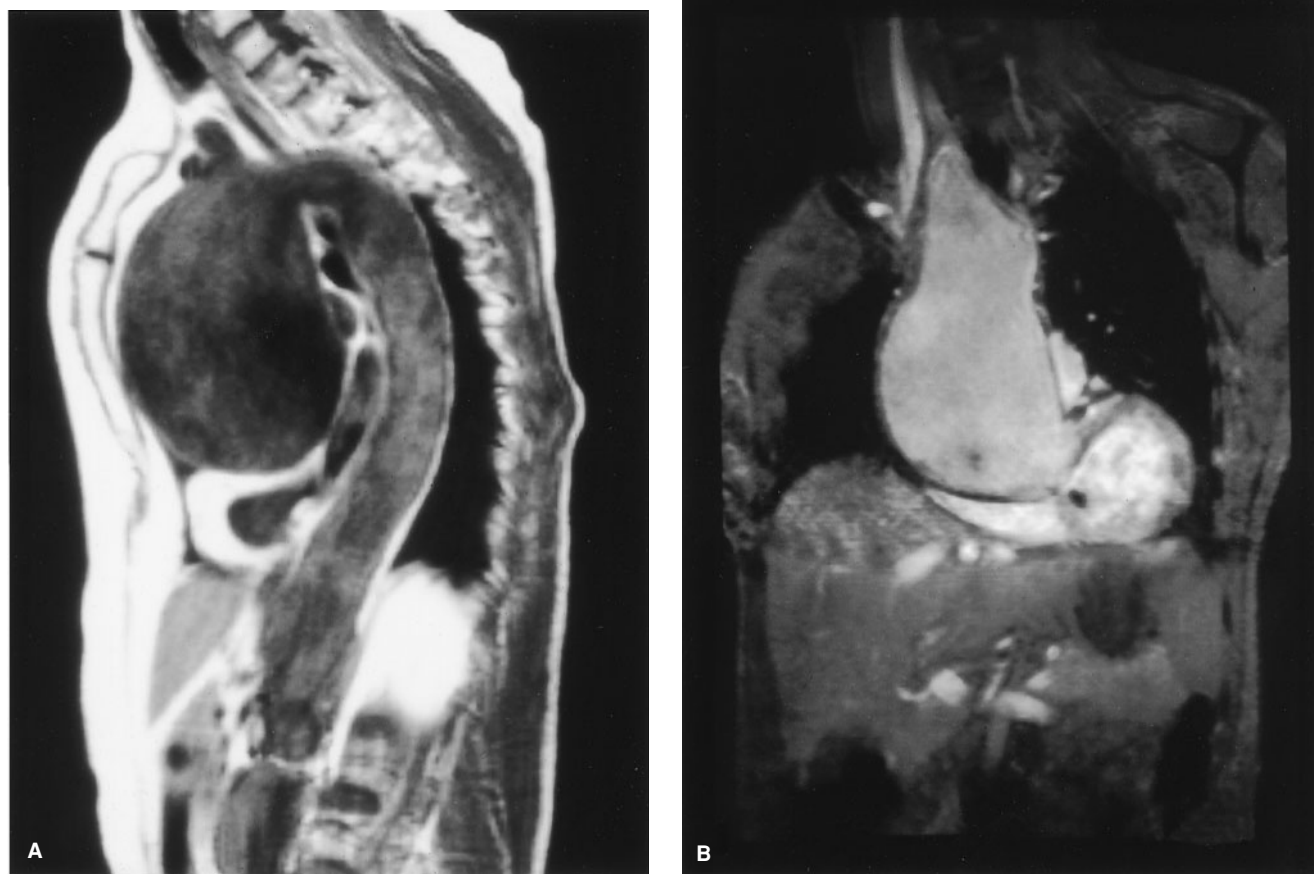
Magnetic resonance image of ascending aortic aneurysms demonstrating sagittal (A) and coronal (B) views. The origin of the innominate artery and its relationship to the distal portion of the aneurysm can be appreciated on the sagittal view. (Images provided courtesy of Kent E. Yucel, MD.)
